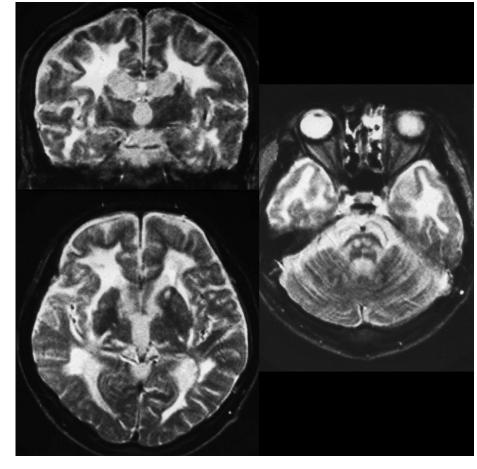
T2-weighted MRI of the patient shown in Figure 1 revealing diffuse confluent HSI areas in the cerebral white matter extending to the anterior temporal lobe and internal and external capsules, as well as small lesions in the basal ganglia and brainstem.
